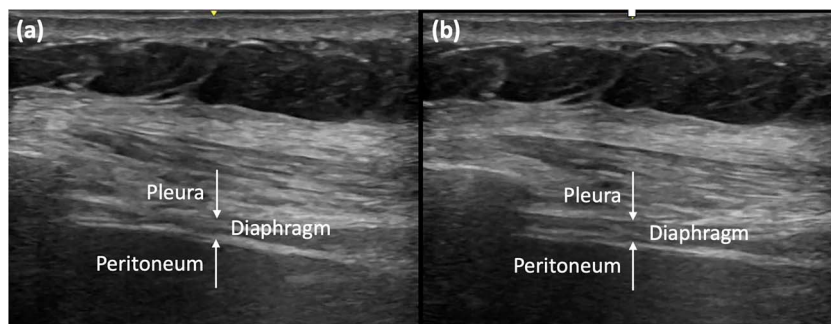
Ultrasonographic images of diaphragms. (a) Diaphragm at the end-expiratory stages. (b) Diaphragm at the end-inspiratory stages, showing that it did not thicken.
